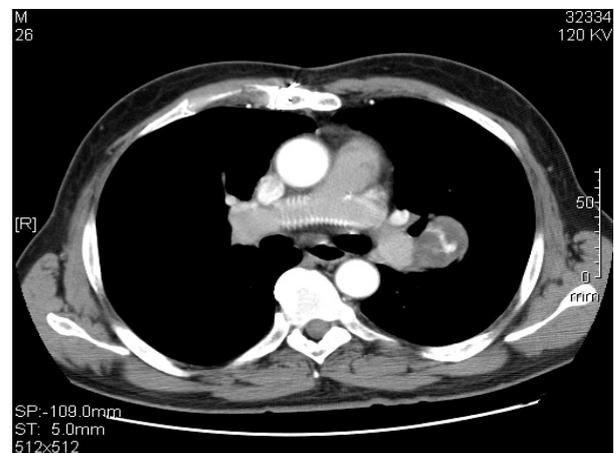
Computed tomographic scan six months after operation showing a left hilar tumor arising from the interlobar portion of the pulmonary artery.
